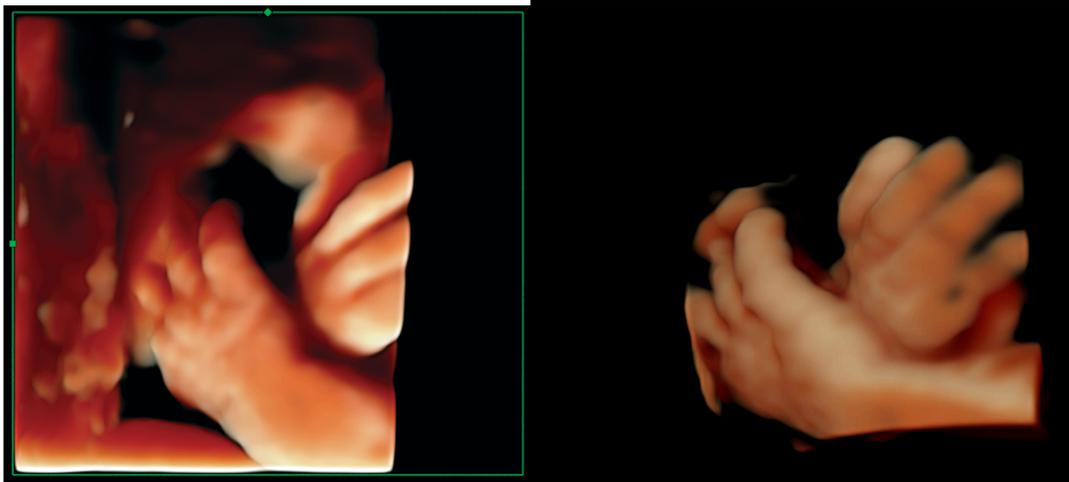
HDlive images demonstrating the anatomic structures of the fetal fingers; the anatomy of the fetal hand depicted by 3D ultrasound and HDlive technology.
